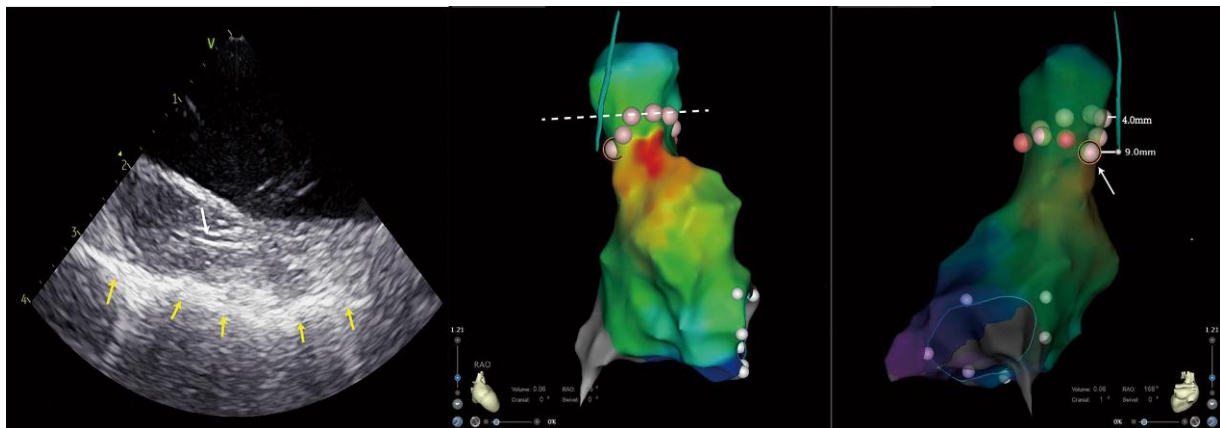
Circumferential superior vena cava (SVC) ablation using intracardiac echocardiography (ICE). Left image: the right phrenic nerve (RPN) imaging under ICE. The up row of arrow indicates the RPN, and the bottom row of arrows indicate the mediastinal pleura. Middle and right images: the same patient's circumferential SVC ablation in the 3D activation map of the right atrium (RA) and SVC in right anterior oblique (RAO) 45° and RAO 168° views. The dotted line indicates the regular circumferential superior vena cava isolation ablation line. The arrow indicates the last ablation point which is the closest ablation point of our actual circumferential superior vena cava ablation.
